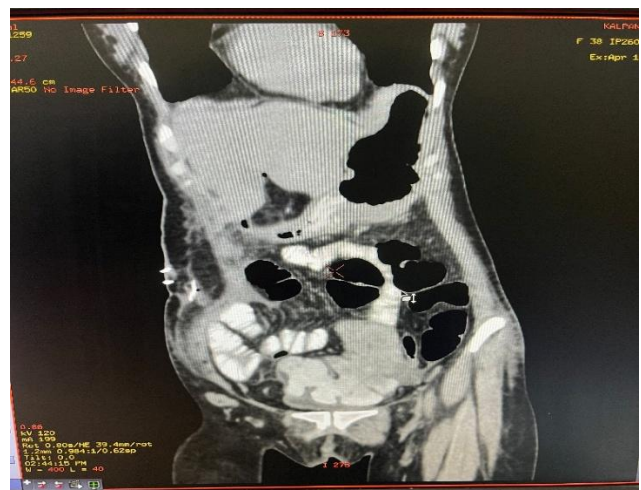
Alignment of bowel in CT scan.
